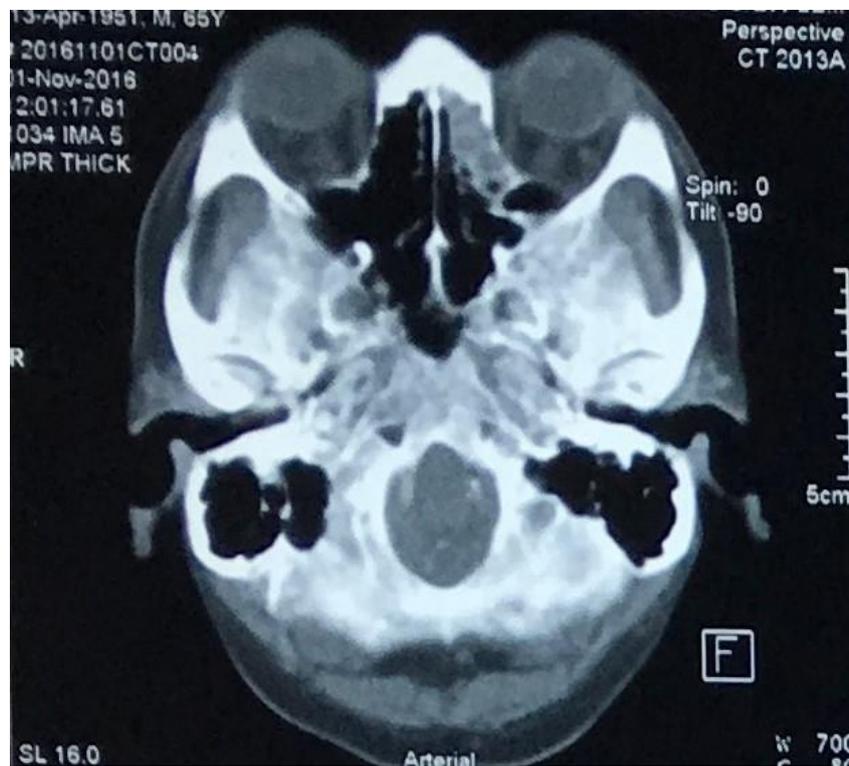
CT Brain & Orbit showed mucosal thickening in left ethmoidal and left maxillary sinuses. No obvious enhancing large retro-orbital mass. No pseudotumour seen. The recti muscles of both orbits were not enlarged. Eyeballs were grossly intact.
